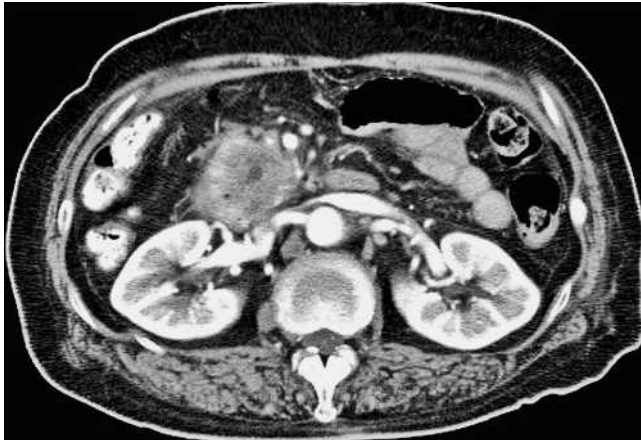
Abdominal computed tomography showed a hypovascular mass in the head of the pancreas, with tumor invasion into the second portion of the duodenum.
